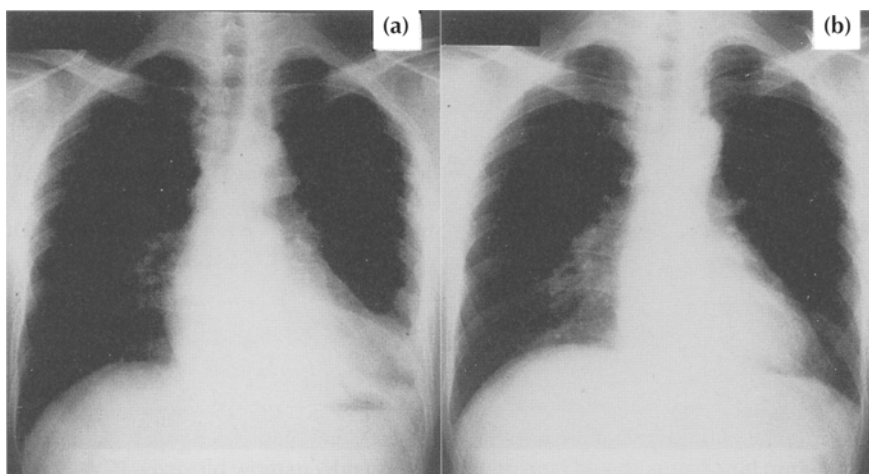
(a) Chest radiograph obtained at time of referral to the authors (September 30, 1994) of a 37-year-old man with symptoms of fever and pain in his left chest. Multiple nodular lesions are visible in the left lung field. (b) Chest radiograph obtained the following March 10 (approximately 22 weeks later) shows almost complete regression of lesions.
